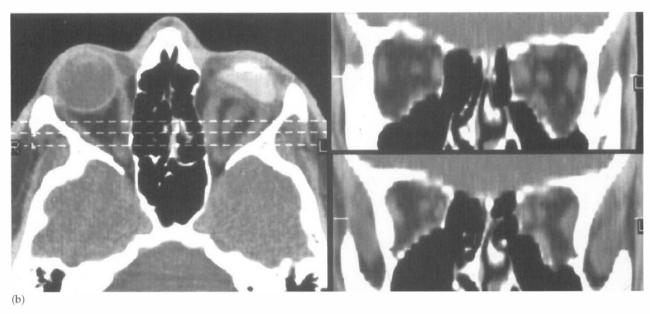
Case 2. (a) Clinical appearance at presentation. (b) CT coronal reconstruction showing a large left anterior floor fracture and a small posterior medial wall fracture. (c) Appearance following fracture repair and secondary hydroxyapatite implant insertion.
